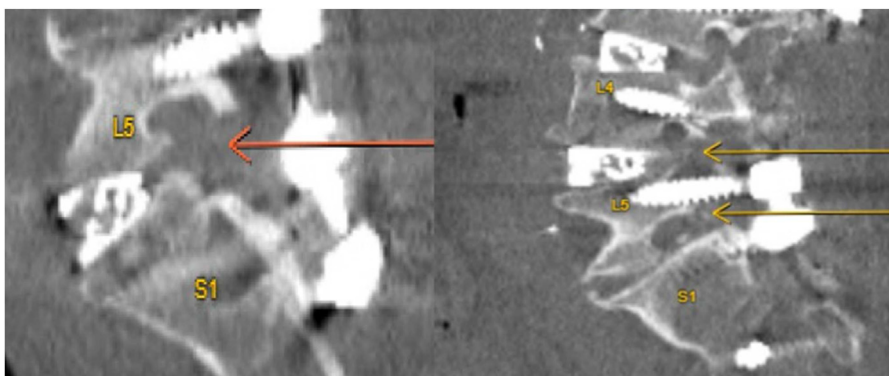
Postoperative CT scan of a patient who received L4-5 and L5-S1 posterior column osteotomies in addition to L3-S1 ALIF and T2-pelvis posterior spinal instrumented fusion. This demonstrates the complete facetectomies involved in posterior column osteotomies. The arrows note the region where the facets have been removed.
